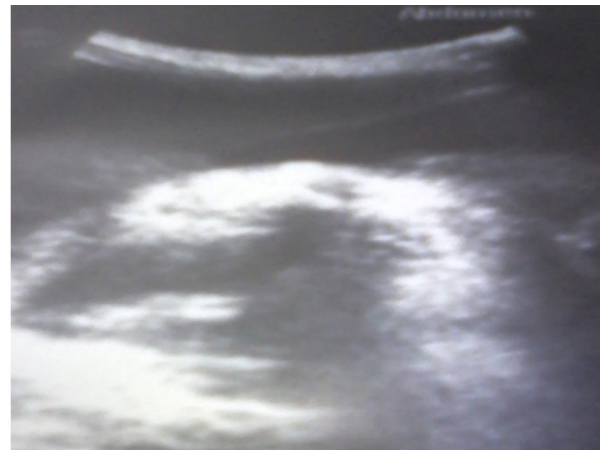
Very thin septum on ultrasonography at level of inguinal ring.
